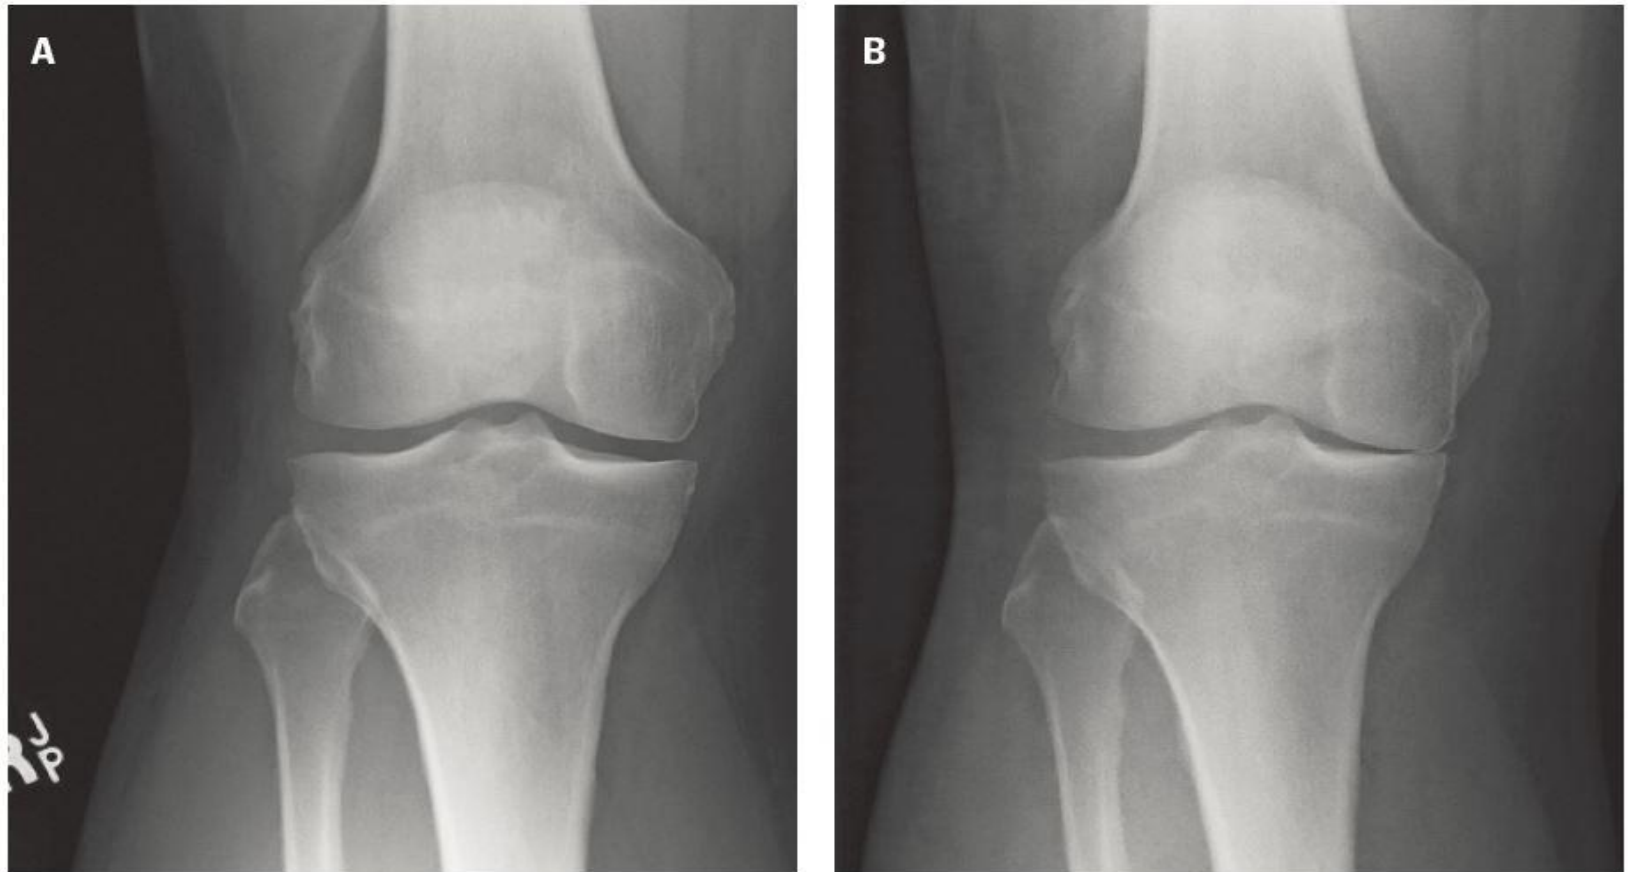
Two anteroposterior radiographs of the same knee. The non-weight-bearing radiograph (A) shows minimal medial joint space loss, while the weight-bearing radiograph (B) reveals significant loss.
